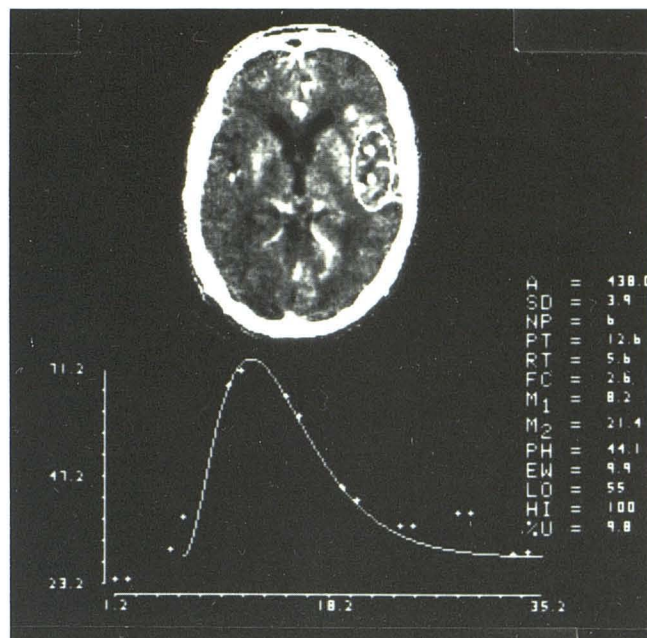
Curve fit relating change in density in left sylvian vessels over time after rapid bolus contrast injection. This program permits examination of a number of parameters including: area under curve (A); standard deviation (SD); number of points (NP); peak time (PT) (the time of greatest curve height); rise time (RT) (time between contrast appearance and peak concentration); falling portion of curve (FC) (the exponential decline of a gamma variate); first moment (M1) (measure of mean time); second moment (M2) (measure of curve width); peak height (PH) and equivalent width (EW) (area under curve divided by height, which is another measure of curve width). LO and HI = CT number range; %U = percentage of histogram-selected pixels within total elliptical area selected.
